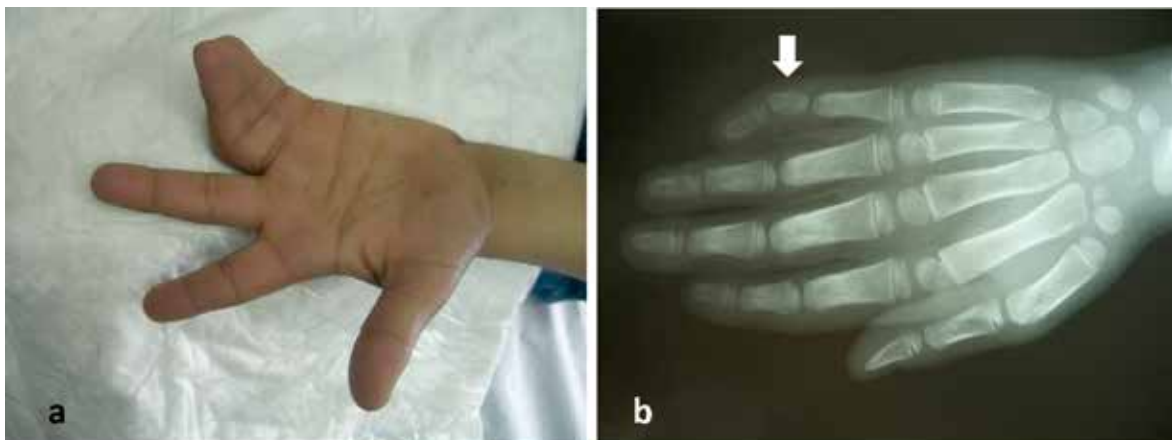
A 2.5-year-old male toddler with a simple-complete syndactyly at the 4th inter-digital web space of the left hand (patient 19). a) Preoperative clinical picture b) A hand x-ray where the presence of a deltoid middle phalanx of the small finger is indicated (arrow).
